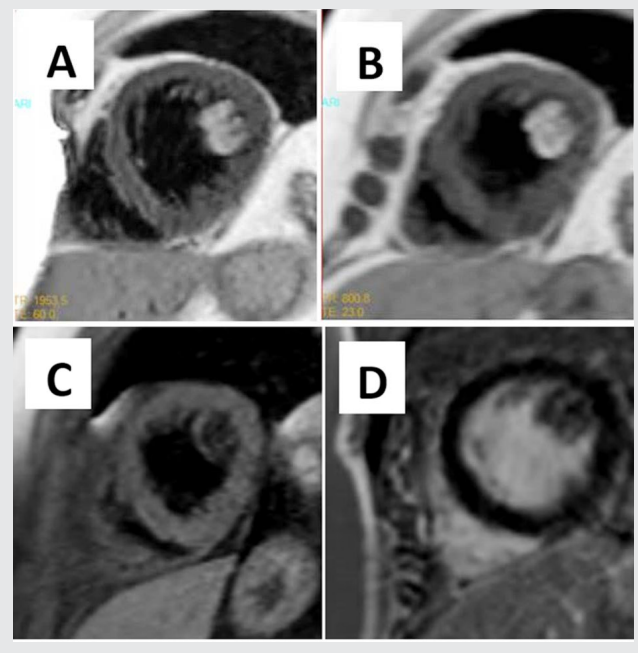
T1W sequences of the elongated predominantly fat-containing at diagnosis (A) measuring 49 x 18 mm, and on the third annual follow up MRI (B) measuring 51 x 16 mm.
